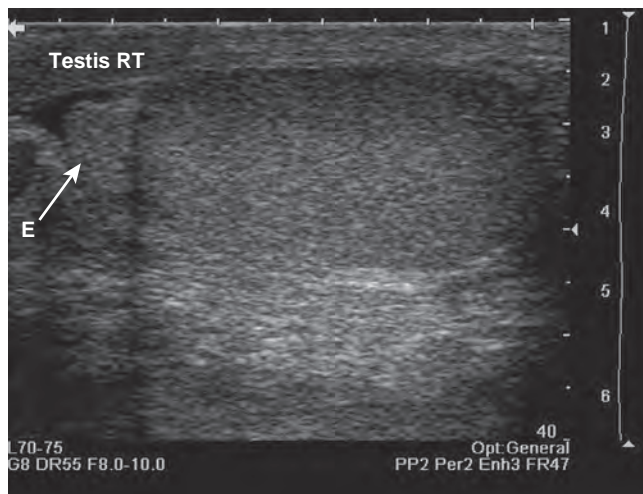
In this longitudinal view, the head of the epididymis (E) is seen to the left, and the lower pole of the testis is to the right. Normal testicular sonographic anatomy is characterized by a homogeneous, finely granular appearance of the testis.
